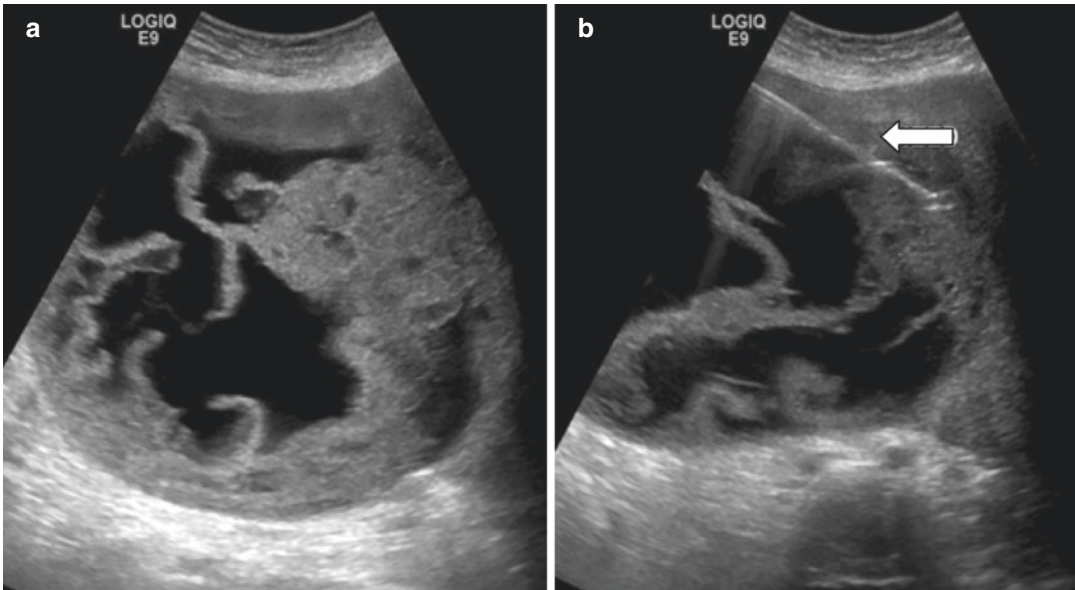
Ovarian cancer. (a) Ultrasound showing a solid cystic adnexal mass with irregular, thick internal septations and solid components. (b) US guided biopsy was
